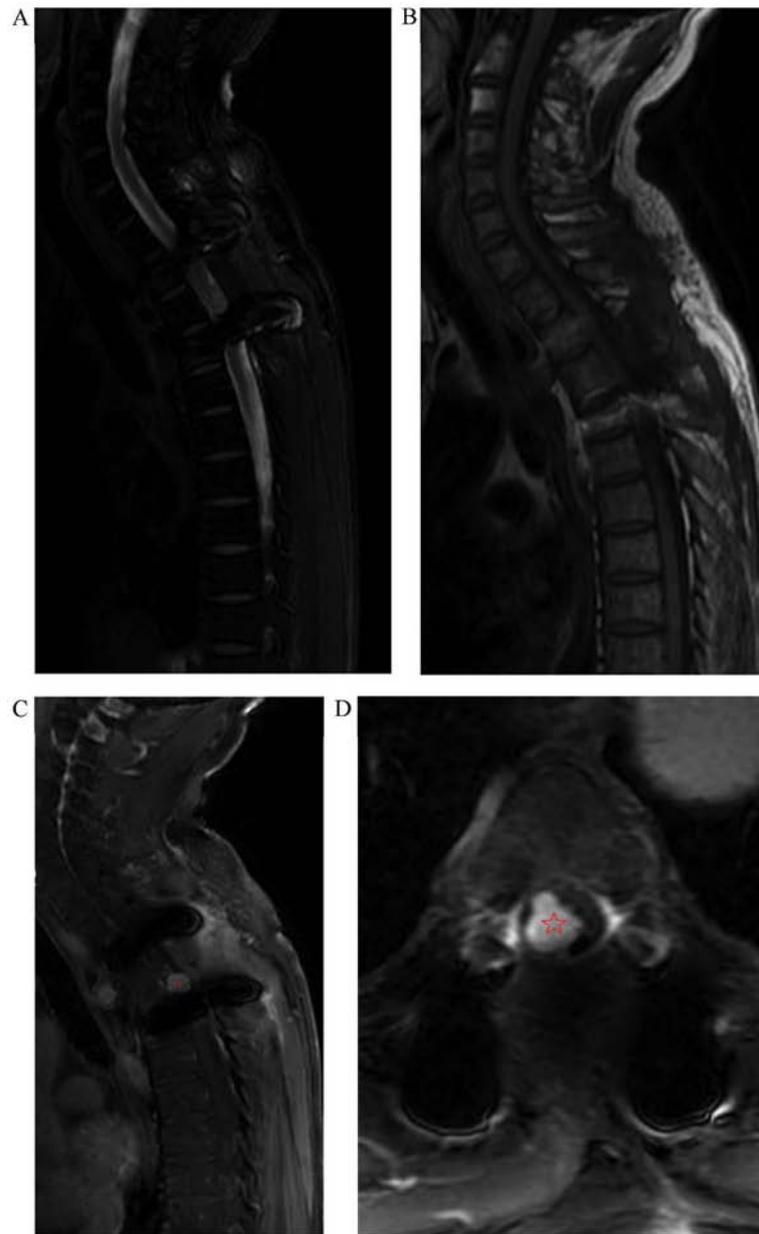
MRI images before the second operation. (A) Sagittal Short T1 Inversion Recovery (TR 2000, TE 98.6) and (B) T1-weighted image (TR 2811, TE 24.1) images display an intradural mass at T3 level. (C) Mass with significant enhancement (TR 150, TE 2.2). (D) Axial T1-weighted image (TR 180, TE 1.8.) indicates that the lesion developed more than 4 months before the first operation. The star indicates the intradural mass. TR, repetition time; TE, echo time.
